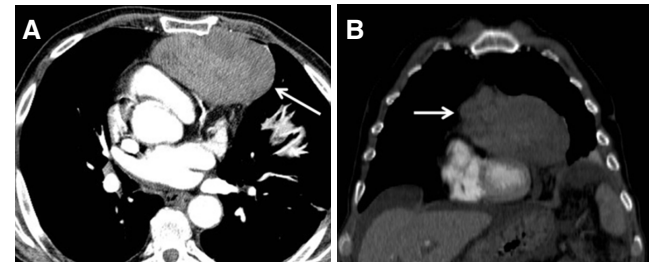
Axial contrast-enhanced computed tomography (CT) slice (A) and coronal reconstruction of CT scan (B). Note large heterogeneous hypervascular anterior mediastinal mass (arrow) posteriorly compressing the right atrium and pulmonary artery
